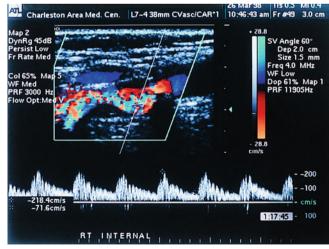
A color duplex ultrasound image of an internal carotid artery showing Doppler spectra of severe stenosis (50-<80%). The peak systolic velocity on this patient was 218.4 cm/s with an end-diastolic velocity of 71.6 cm/s
